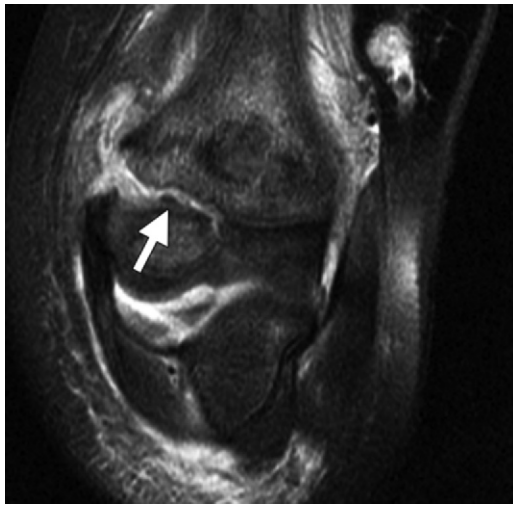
Lateral condylar fracture in the elbow of a 5-year-old boy. Coronal fat-suppressed T2-weighted MR image shows a fracture affecting the distal humeral physis and metaphysis that extends into the cartilaginous epiphysis (Salter-Harris IV) (arrow). A small joint effusion and adjacent soft-tissue edema are also seen.
